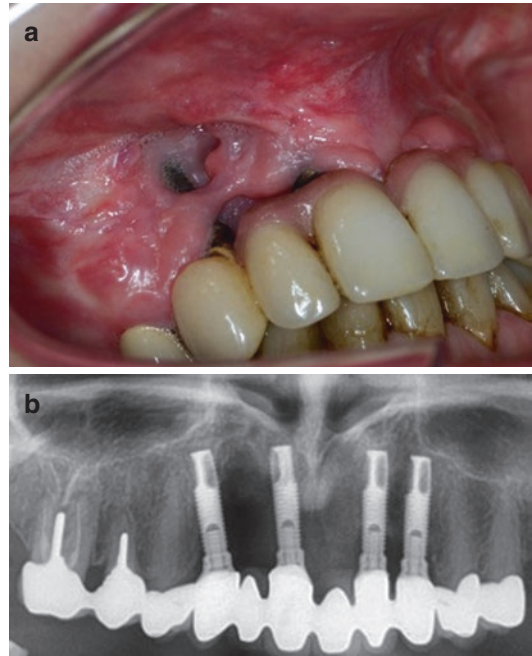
(a) Surgery over exposed implants enhances the risk of breakdown of a thin mucosal flap. (b) Panoramic radiograph
